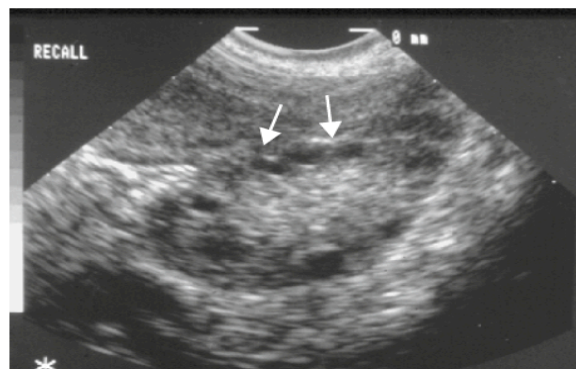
Transvaginal ultrasound in a woman with polycystic ovarian disease. The multiple subcapsular cysts, with their "string of pearls" appearance (arrows), are common in this syndrome.
